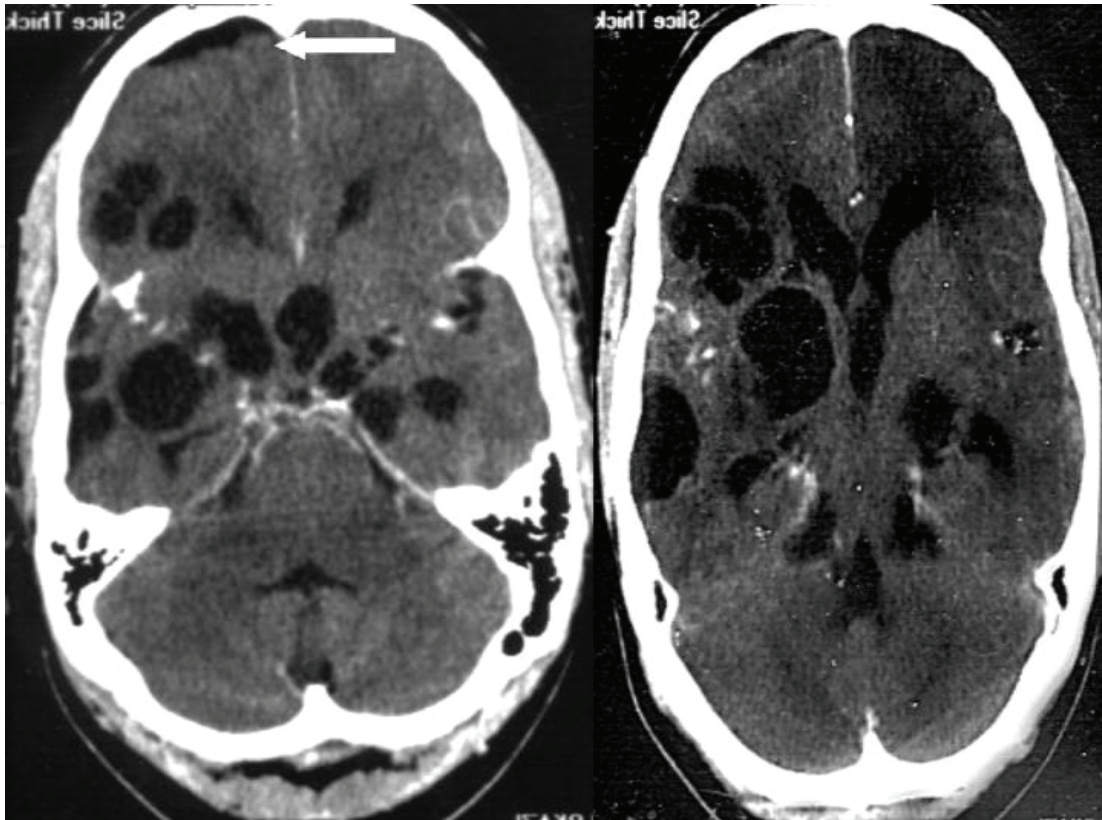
CT scans of the brain show SA-NC (Racemose's presentation)
